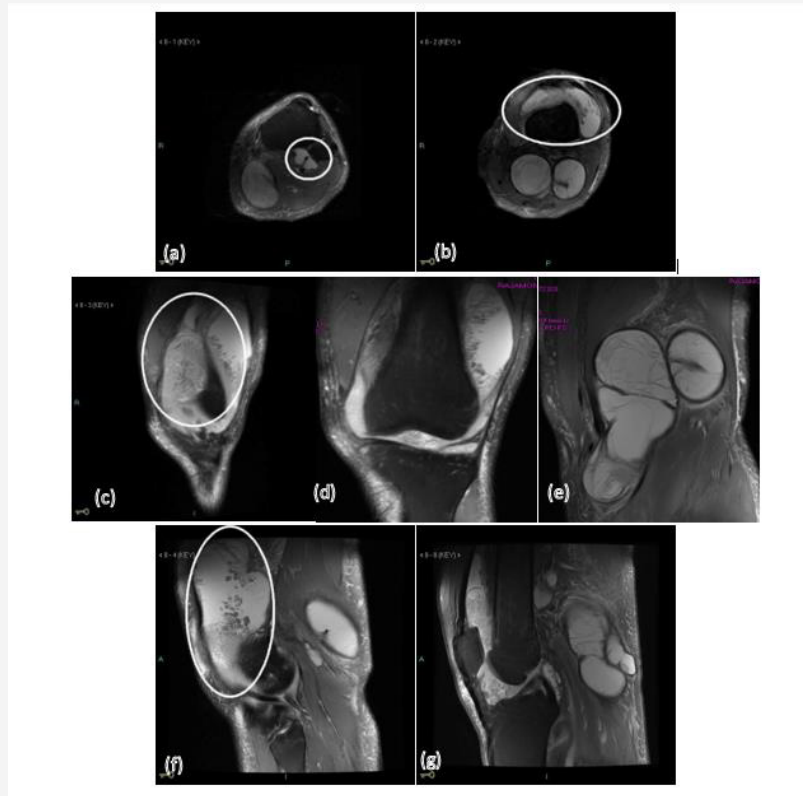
MR images of left knee on T1-weighted (a) and (b) axial PD-weight with fat saturation, (c), (d) and (e) coronal PD-weight with fat saturation, (f) sagittal PD-weight with fat saturation, (g) sagittal T2 ACL THIN.
